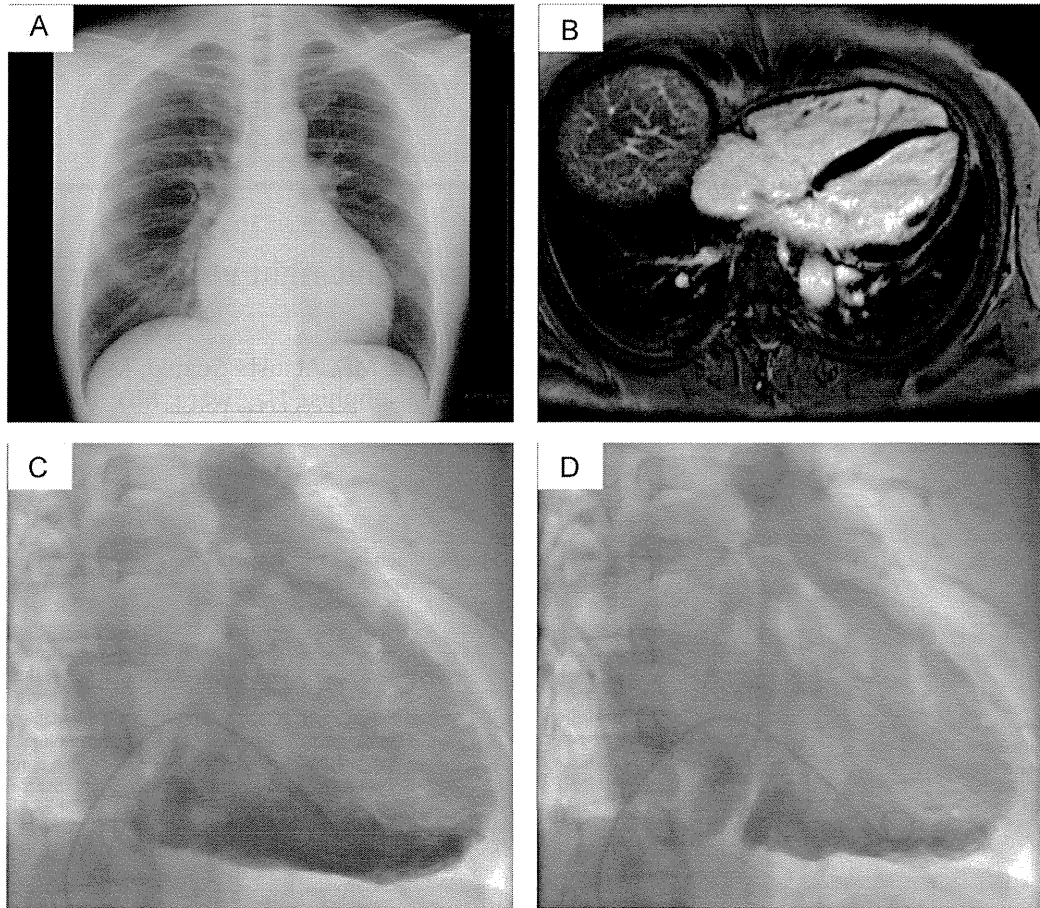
(A)Chest radiograph reveals mild right ventricle dilatation. (B) Cardiovascular magnetic resonance imaging shows mild right ventricle dilatation and no late gadolinium enhancement. (C) Right ventricular angiography demonstrates right ventricular dilatation and akinesis in the inferior wall. (D) Computed tomography does not reveal fatty change in the right ventricular myocardium.
